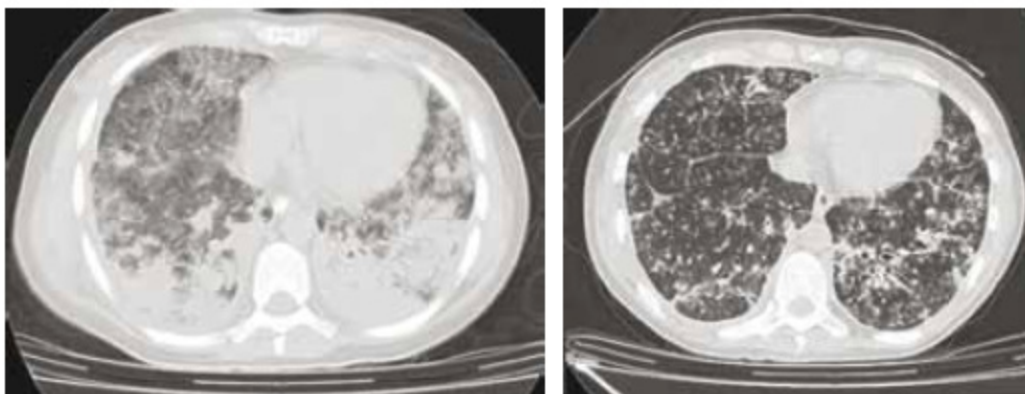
Chest computed X-ray tomography of a patient with life-threatening pulmonary tuberculosis, on hospital day 13 (left) and day 63 (right). Adjunctive treatment with the anti-TNF monoclonal antibody adalimumab, initiated on day 17, was followed by a rapid therapeutic response. Modified with permission from reference ⁷⁸.
